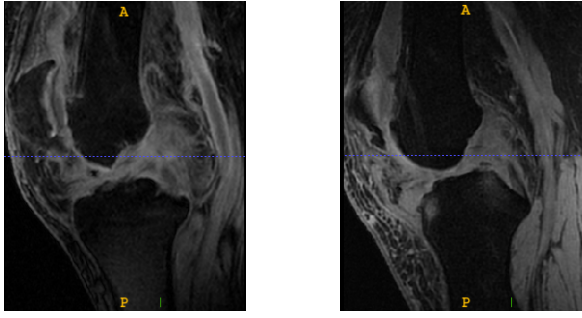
Intensity variability. Both images correspond to MRI of knees, but the range of intensities differs between them.
